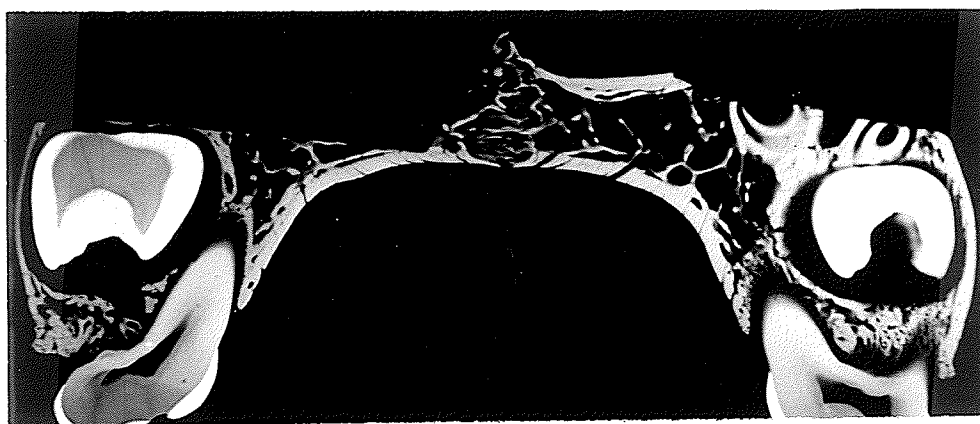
Soft x-ray radiograph of midpalatal suture region. (X4)
